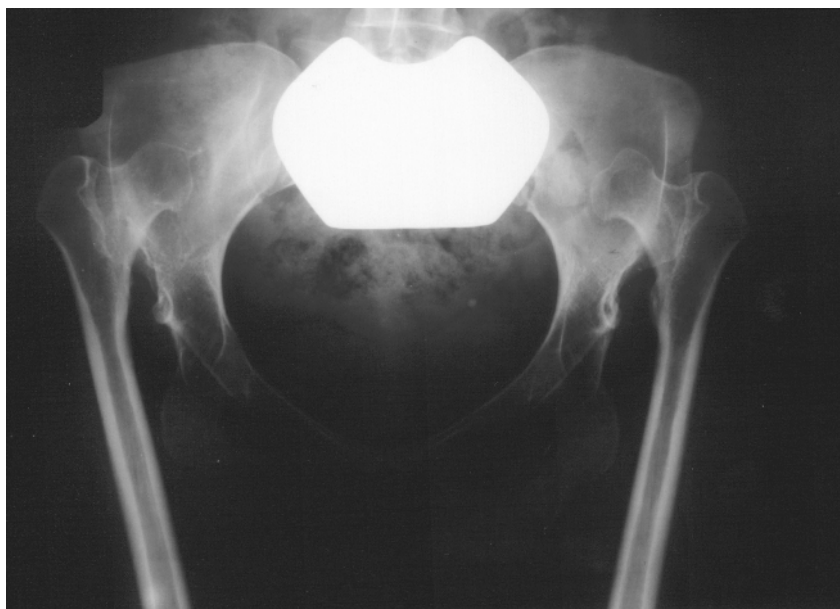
Anteroposterior radiograph of the pelvis demonstrating longstanding bilateral congenital hip dislocation. Both hips have dislocated proximal to the true acetabulum and are posterior to the iliac wings.
